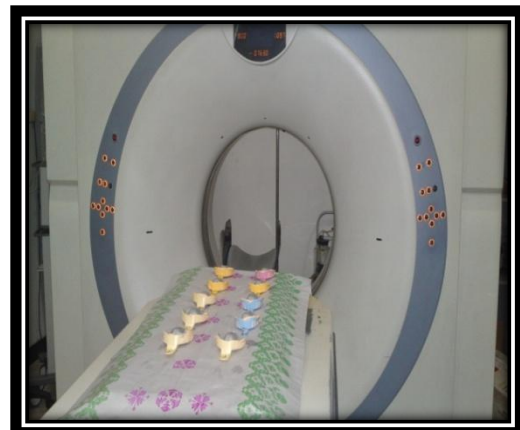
CT scanning of impressions
